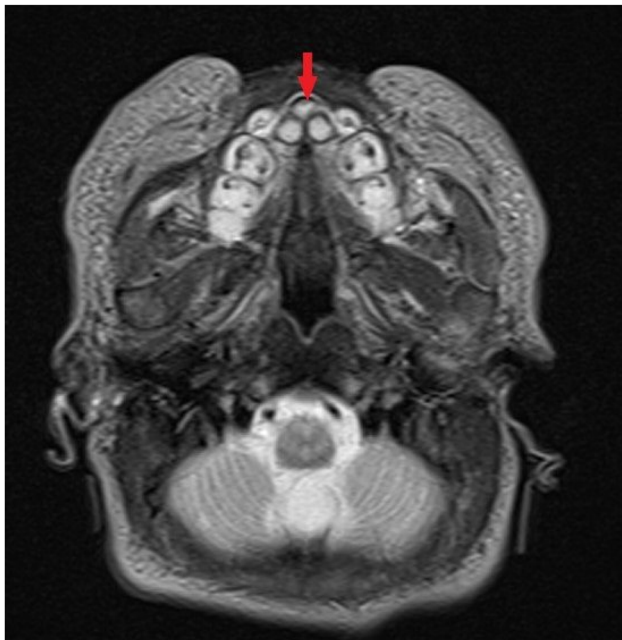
Brain MRI showing solitary central incisor.
